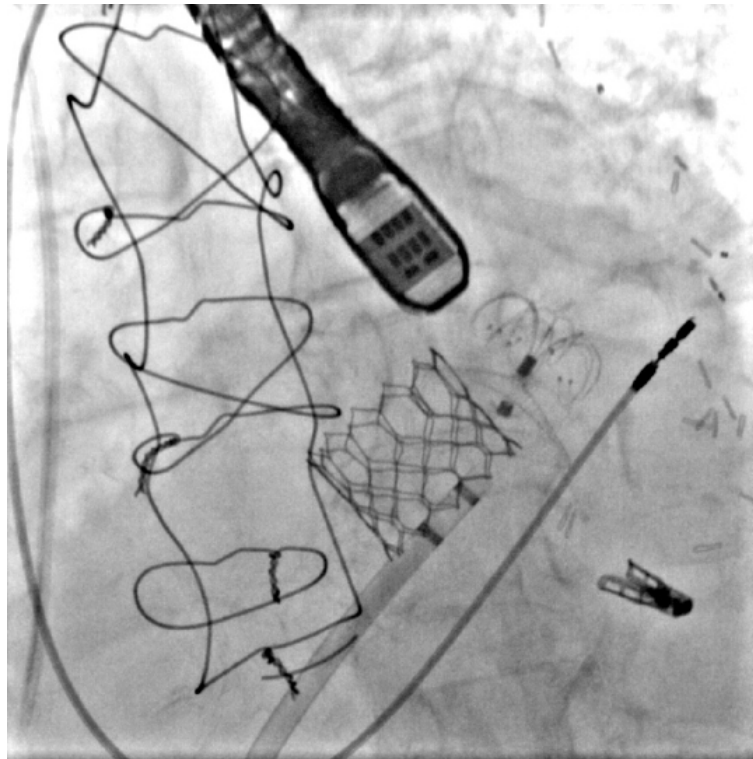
Left atrial appendage (LAA) closed through a patent foramen ovale (PFO). Left: LAmbré device occluding the LAA and a second dedicated device occluding the PFO; right: the same image seen by 3D transesophageal echocardiogram .
